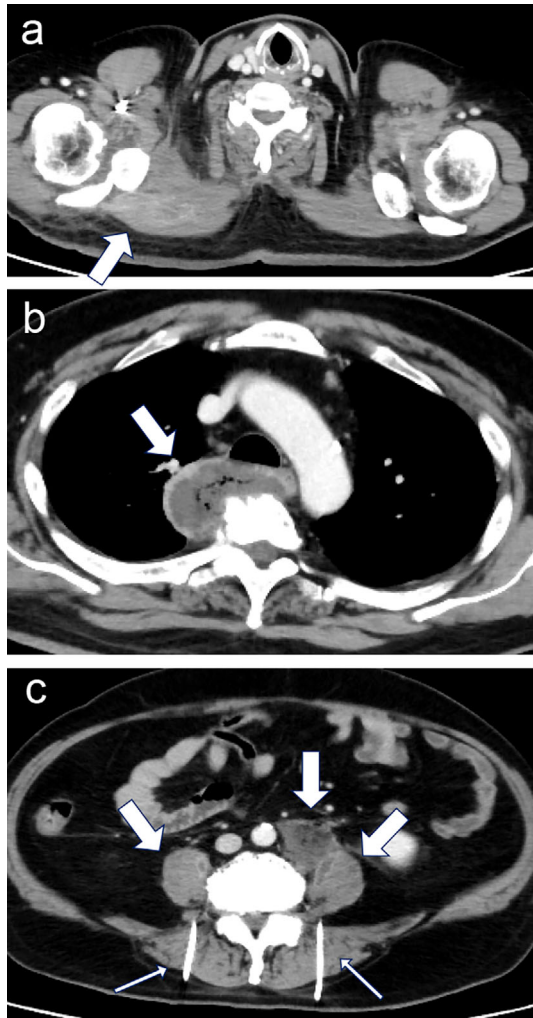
Chest CT scan showing right trapezius muscle swelling (a) and a posterior mediastinal paravertebral abscess (b). Abdominal CT scan showed bilateral psoas muscle abscesses, a left retroperitoneal abscess, and bilateral psoas muscle drainage tubes that were inserted on day 6 (thin arrows) (c).
